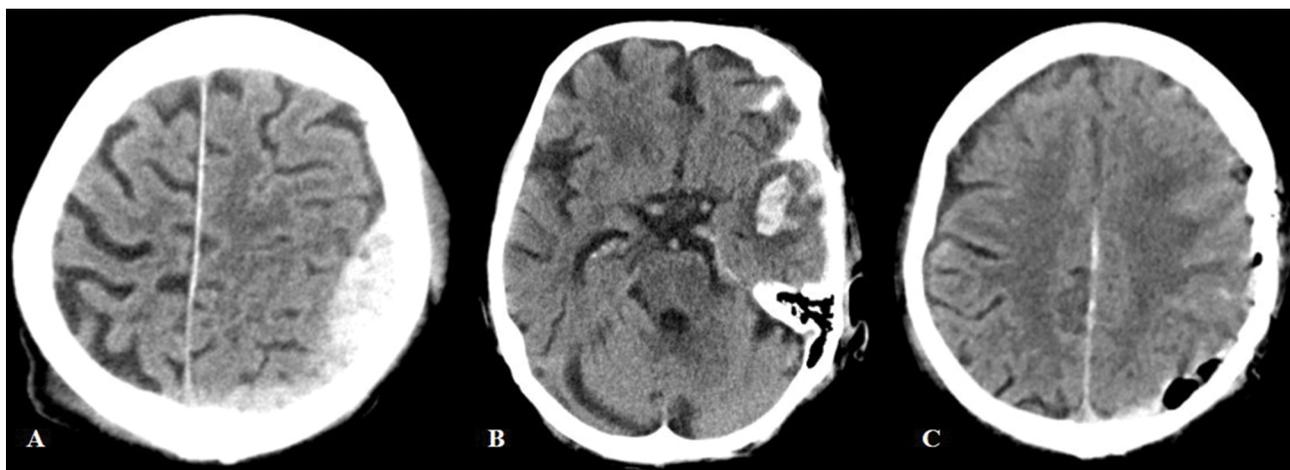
CT of a 69-year-old patient who fell from his own height at home. A) Presence of an epidural hematoma in the left parietal region and edema of the left cerebral hemisphere; B) Presence of a hemorrhagic contusion focus in the left temporal region and traumatic subarachnoid hemorrhage; C) Postoperative CT shows the evacuation of the hematoma.
